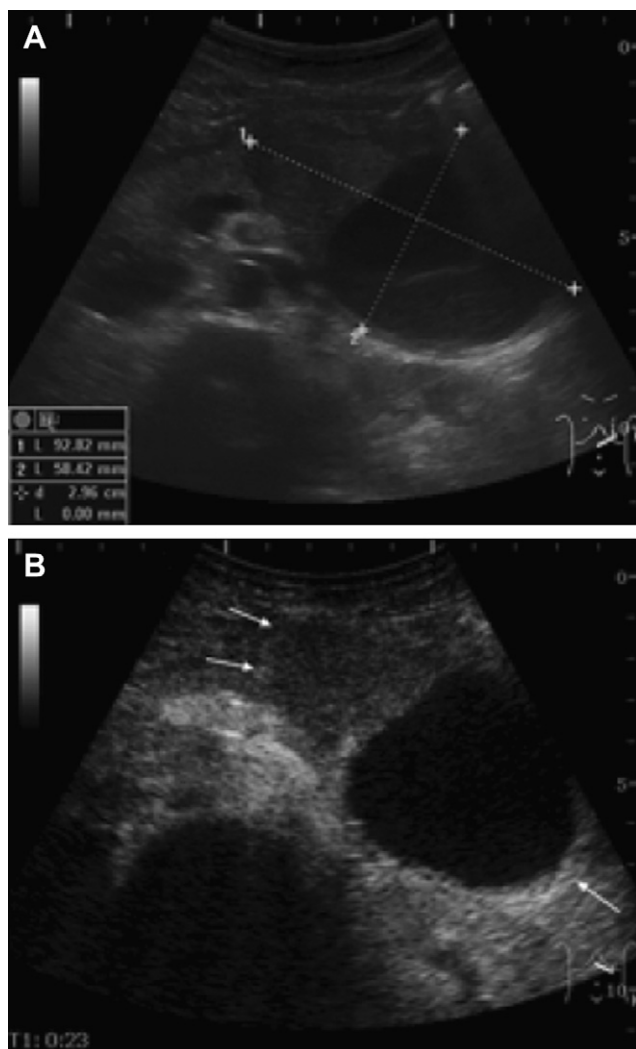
(A) Ultrasound examination (transverse section) showing a well-defined mixed mass in the pancreatic body and tail. (B) Contrast-enhanced ultrasound (transverse section) showing homogeneous filling of the tumor in the arterial phase and the presence of peripheral rim enhancement (arrows).
